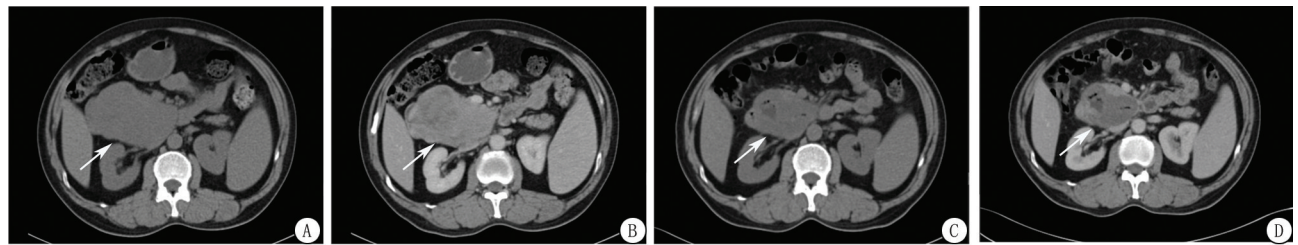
男, 53 岁, 十二指肠间质瘤(箭头所示为靶病灶)。治疗后靶病灶缩小, 内部出现坏死, 平扫、静脉期长径变化率分别为 29.8%、30.3%, CT 值变化率分别为 29.8%、49.1%。参照 RECIST 1.1 及 Choi 标准, 平扫及静脉期评效均为 PR, 评效一致) A. 治疗前平扫图像; B. 治疗前静脉期图像; C. 治疗后平扫图像; D. 治疗后静脉期图像
